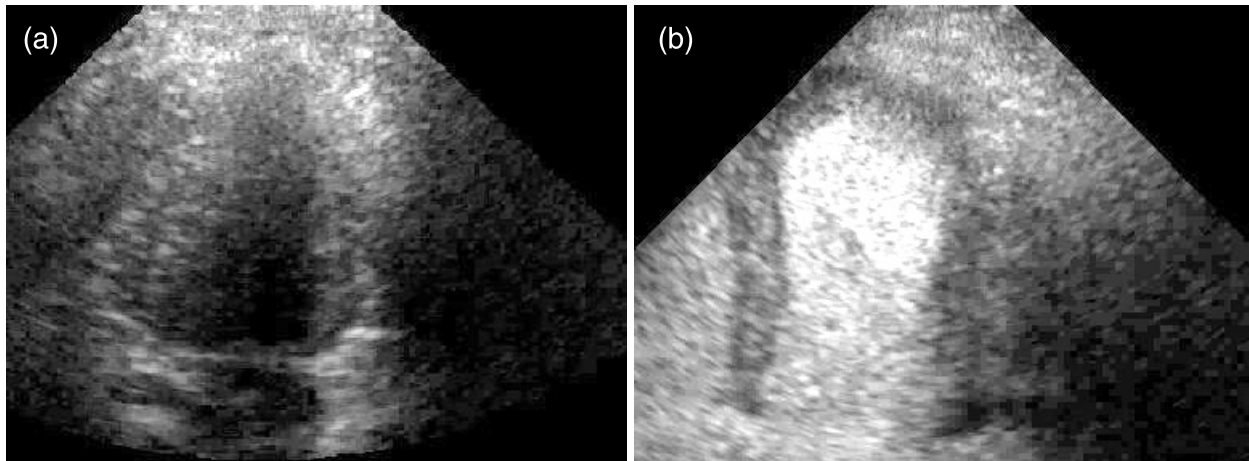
(a) Apical 4-chamber view during fundamental imaging which shows poor delineation of endocardium. (b) Following a contrast injection, there is marked improvement of the endocardial visualisation of the left ventricle.
